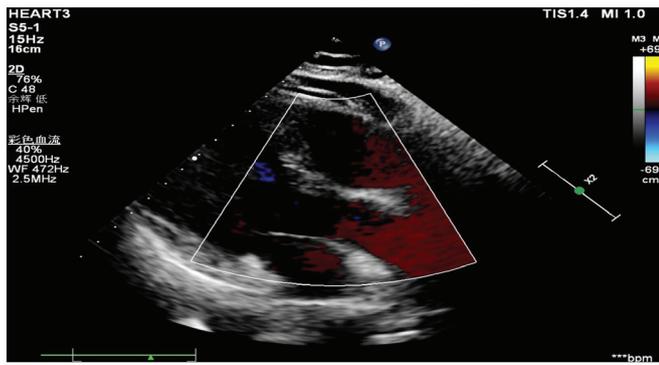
No abnormality in the color Doppler ultrasound scan of the heart.
